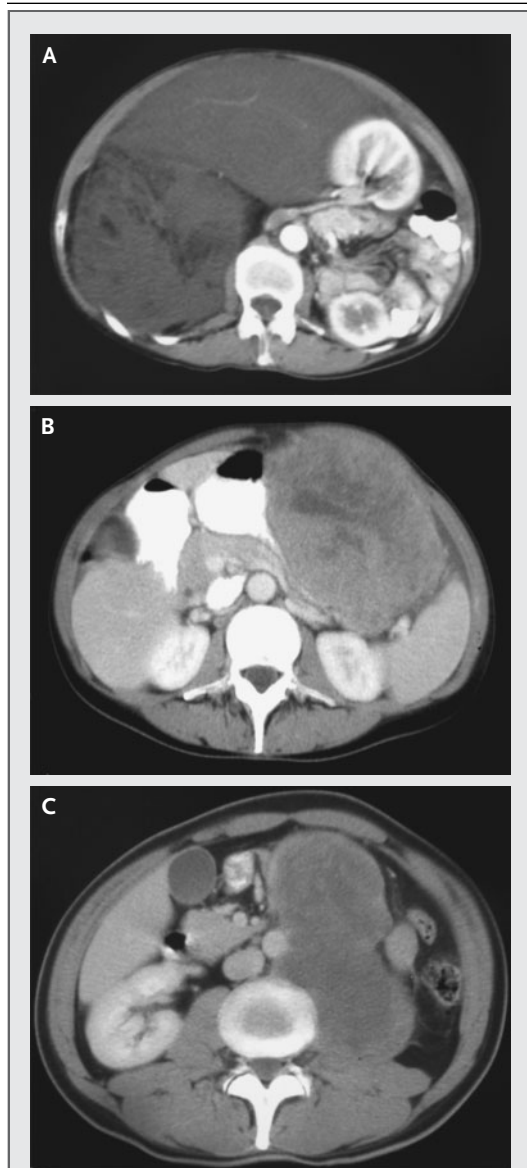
CT Scans of Large Retroperitoneal Masses Suggestive of Soft-Tissue Sarcoma.
